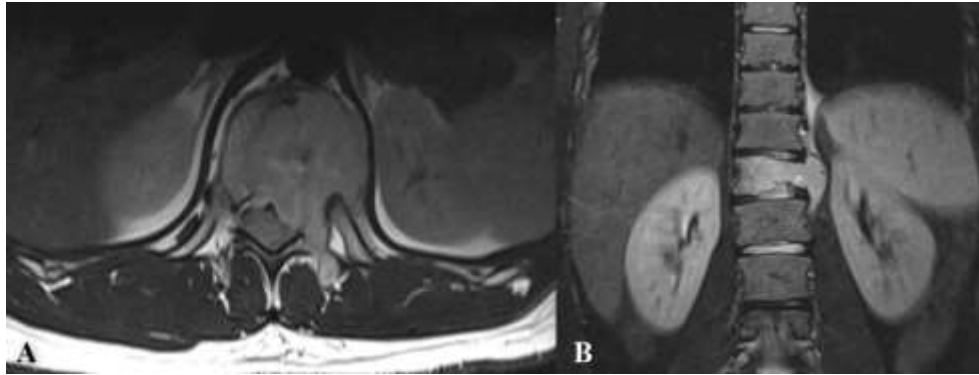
Sarcoma vertebral metastases in a 23 years old male patient MRI - axial T1w (A) and coronal T2w (B) - reveals the vertebral lesion of D11 with high signal intensity on T2w images extending to the left paravertebral space.
